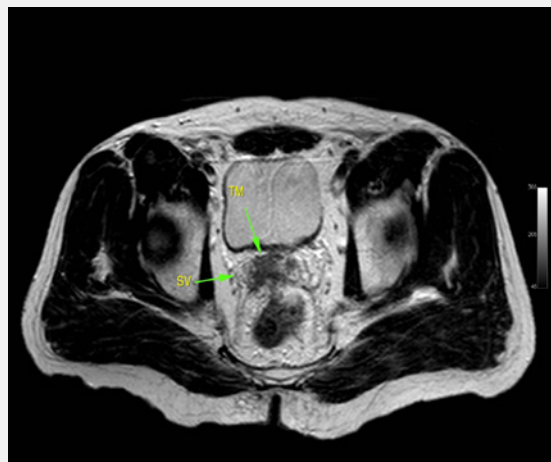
MRI (T2-weighted) reveals a tumor in the right seminal vesicle with an irregular edge (shown with arrows: TM = tumor, SV = seminal vesicle).
